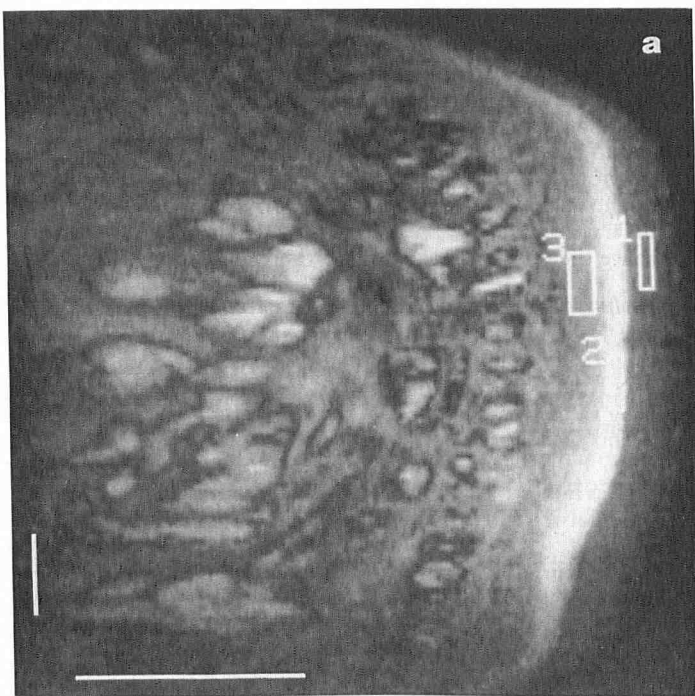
Skin on heel. *a*, magnetic resonance image of skin in vivo on heel. The outer grey layer is stratum corneum, which appears particularly thick in this area; it corresponds to region 1. The brighter layer between stratum corneum and dermis is epidermis, which is also particularly thick (about 500μ in thickness); it corresponds to region 2. Dermis (region 3) appears more homogeneous than in calf. The border between dermis and hypodermis is less delineated than in calf due to the particular texture of hypodermis. Regions 1, 2, and 3 represent some of the five ROI selected in each layer. Bars, 5 mm. *b*, *c*, plots of experimental points and the fitted curves obtained for T1 calculation (*b*) with a spin-echo sequence and five different TR; and for T2 calculation (*c*) with a gradient-echo sequence and four TE values. Presented data are issued from one of the five ROI in each layer. Error bars, standard deviation between pixels of the selected ROI.
